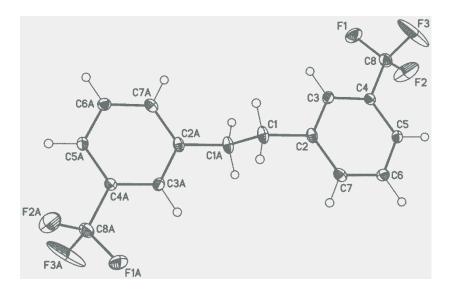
The x-ray structure of compound 20.
